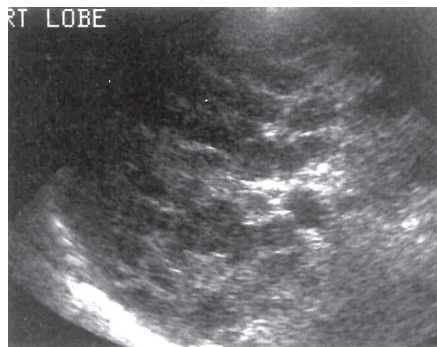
Ultrasound: Hypoechoic regenerating nodules in hepatic cirrhosis
